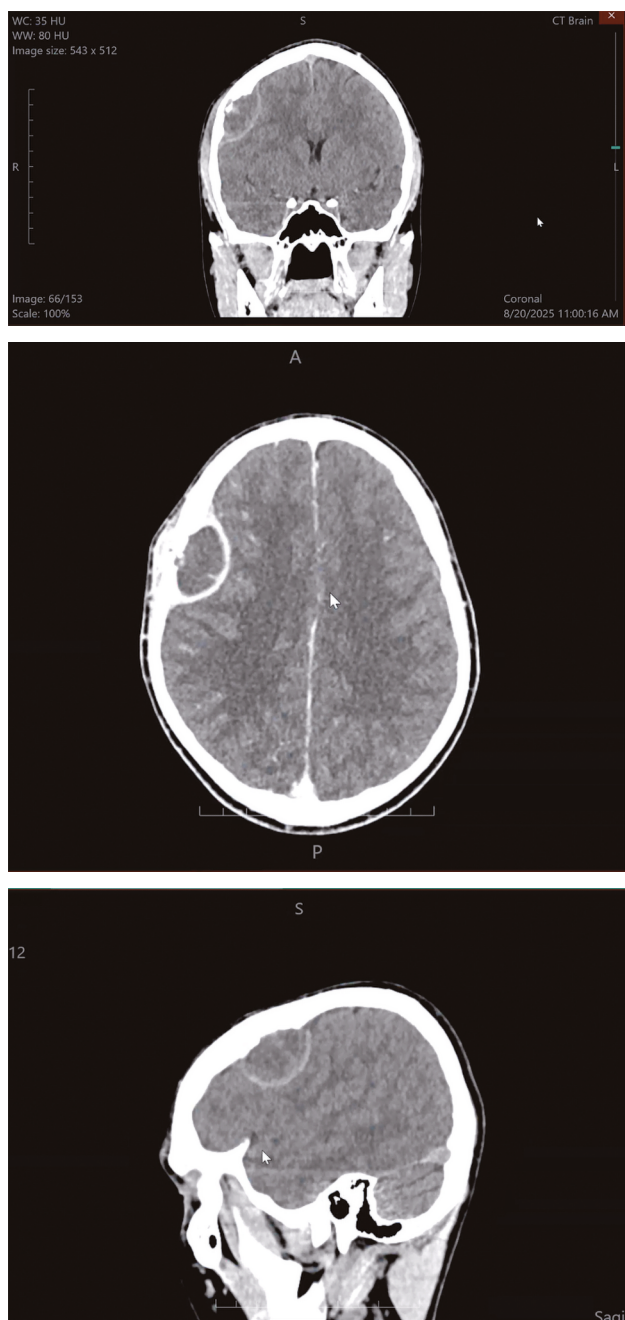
Cranial CT, coronal, axial, and sagittal planes. Osteolytic lesion of the right parietal bone with cortical destruction, extraosseous soft-tissue component, and intracranial extension
